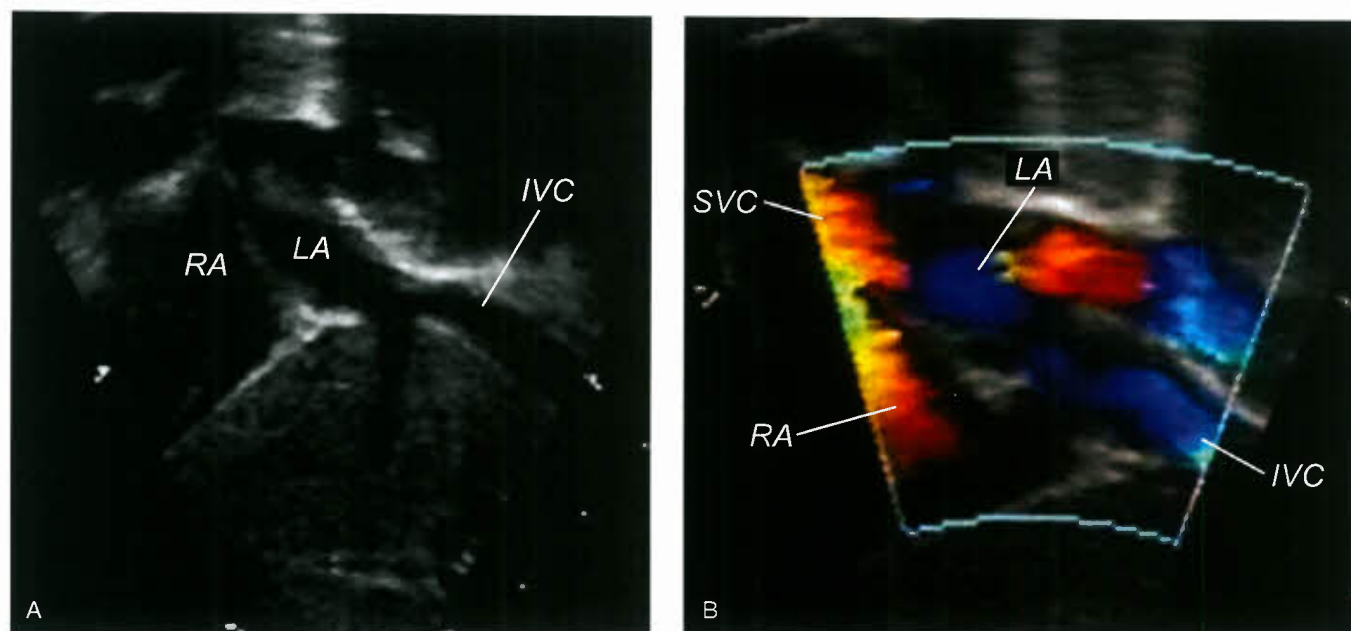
Echocardiogram in a 7-year-old boy with cyanosis. A: Subcostal short-axis image showing drainage of the inferior vena cava (IVC) to the left atrium (LA). B: Color Doppler flow mapping confirms flow from the inferior vena cava (IVC) to the left atrium (LA) and from the superior vena cava (SVC) to the right atrium (RA). At surgery, the atrial septum was resected, and an autologous pericardial patch was placed to the left of the inferior vena cava, thus incorporating it into the right atrium.
